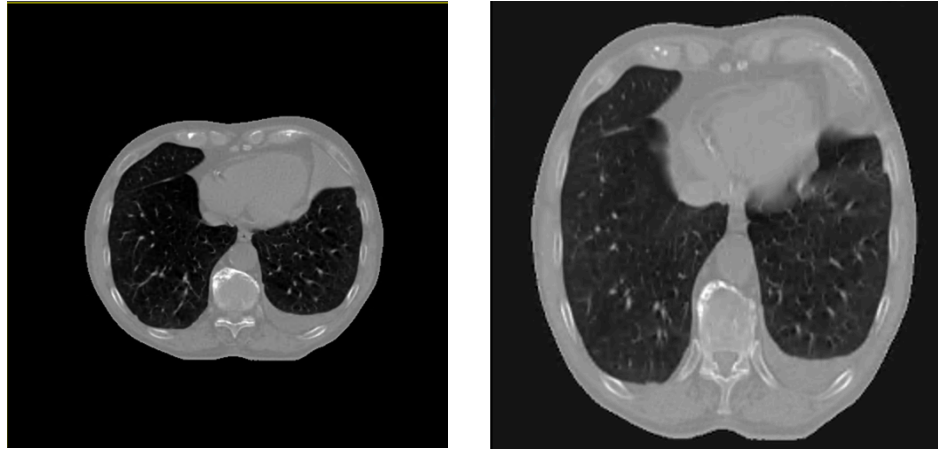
An example of axial slice of original CT image (left) and processed CT image (right)
